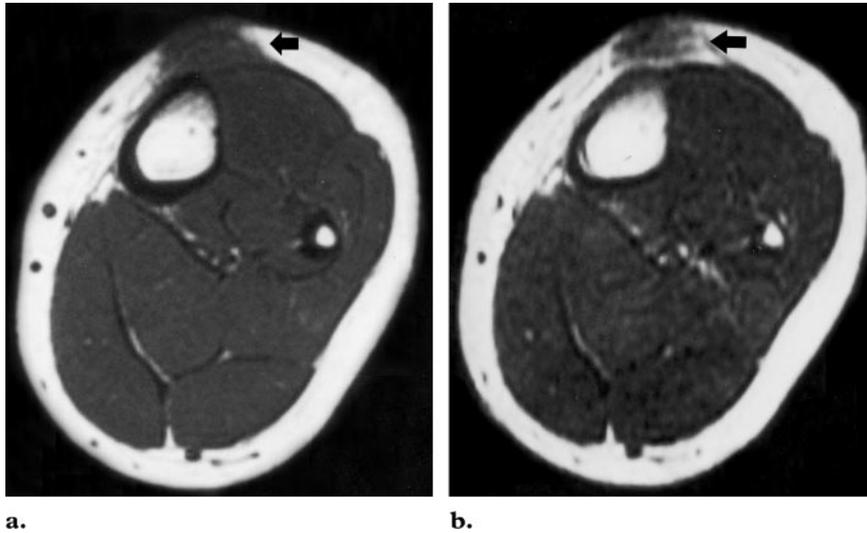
Granuloma annulare in the lower leg of a 5-year-old girl. Axial T1-weighted (500/20) (a) and axial T2-weighted (2000/80) (b) SE MR images show a mass in the subcutaneous tissue of the anterior part of the leg (arrow). The lesion had decreased signal intensity and a somewhat indistinct margin on all MR images.
